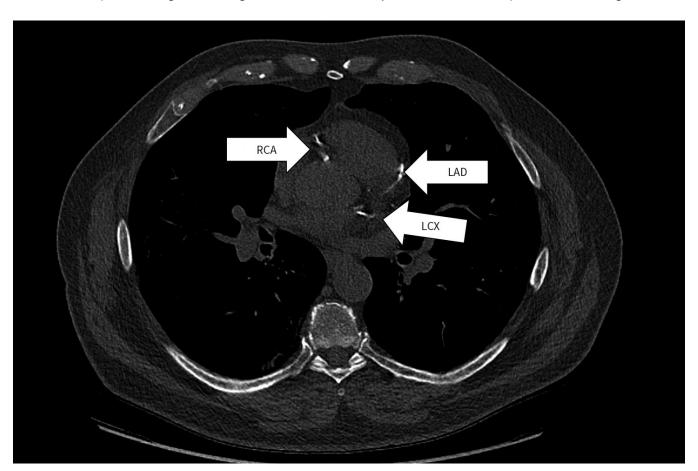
Coronary artery calcification on low-dose chest computed tomography (CT). Transaxial image of a lung cancer screening CT scan, showing coronary artery calcium in all 3 coronary arteries. Note: LAD = left anterior descending artery, LCX = left circumflex artery, RCA = right coronary artery.
